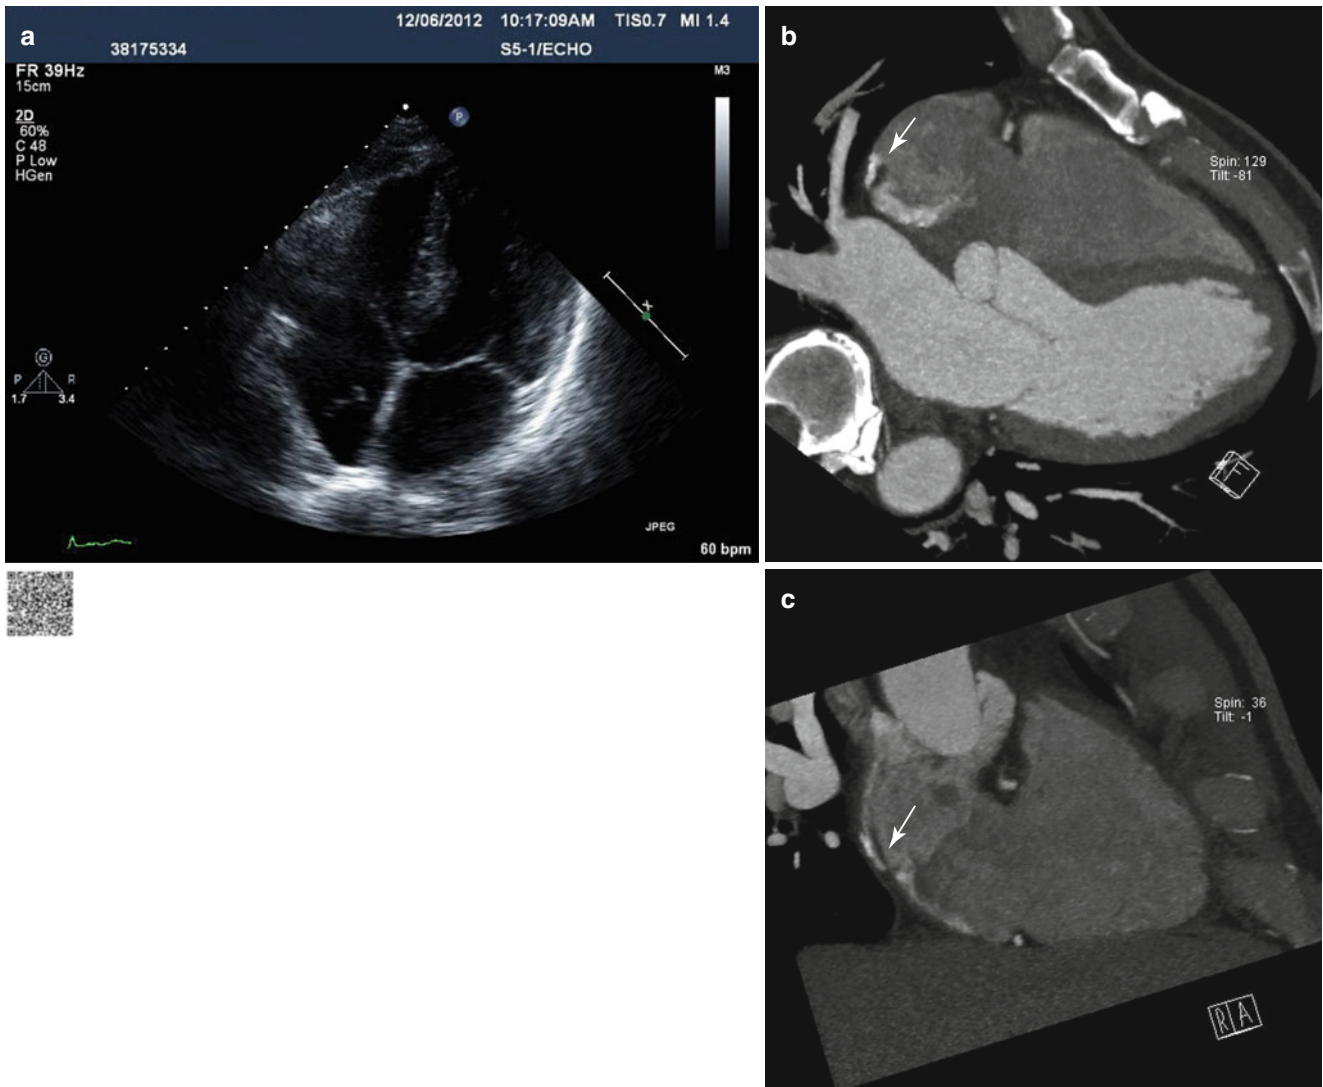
Chiari network. (a) Four-chamber view image using trans-thoracic echocardiography shows the echogenic curvilinear structure attached to the right atrium. This structure shows hypermobility during the cardiac cycle in the cine image ([http://extras.springer.com/2015/978-](http://extras.springer.com/2015/978-3-642-36396-2)
